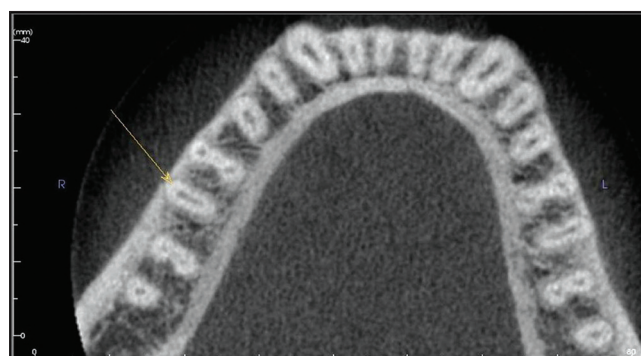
Cone beam computed tomography scan view at the apical third; the three distal canals appear to merge together to exit as a single canal
